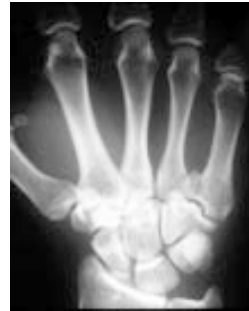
Pre-operative radiograph of case 2.
